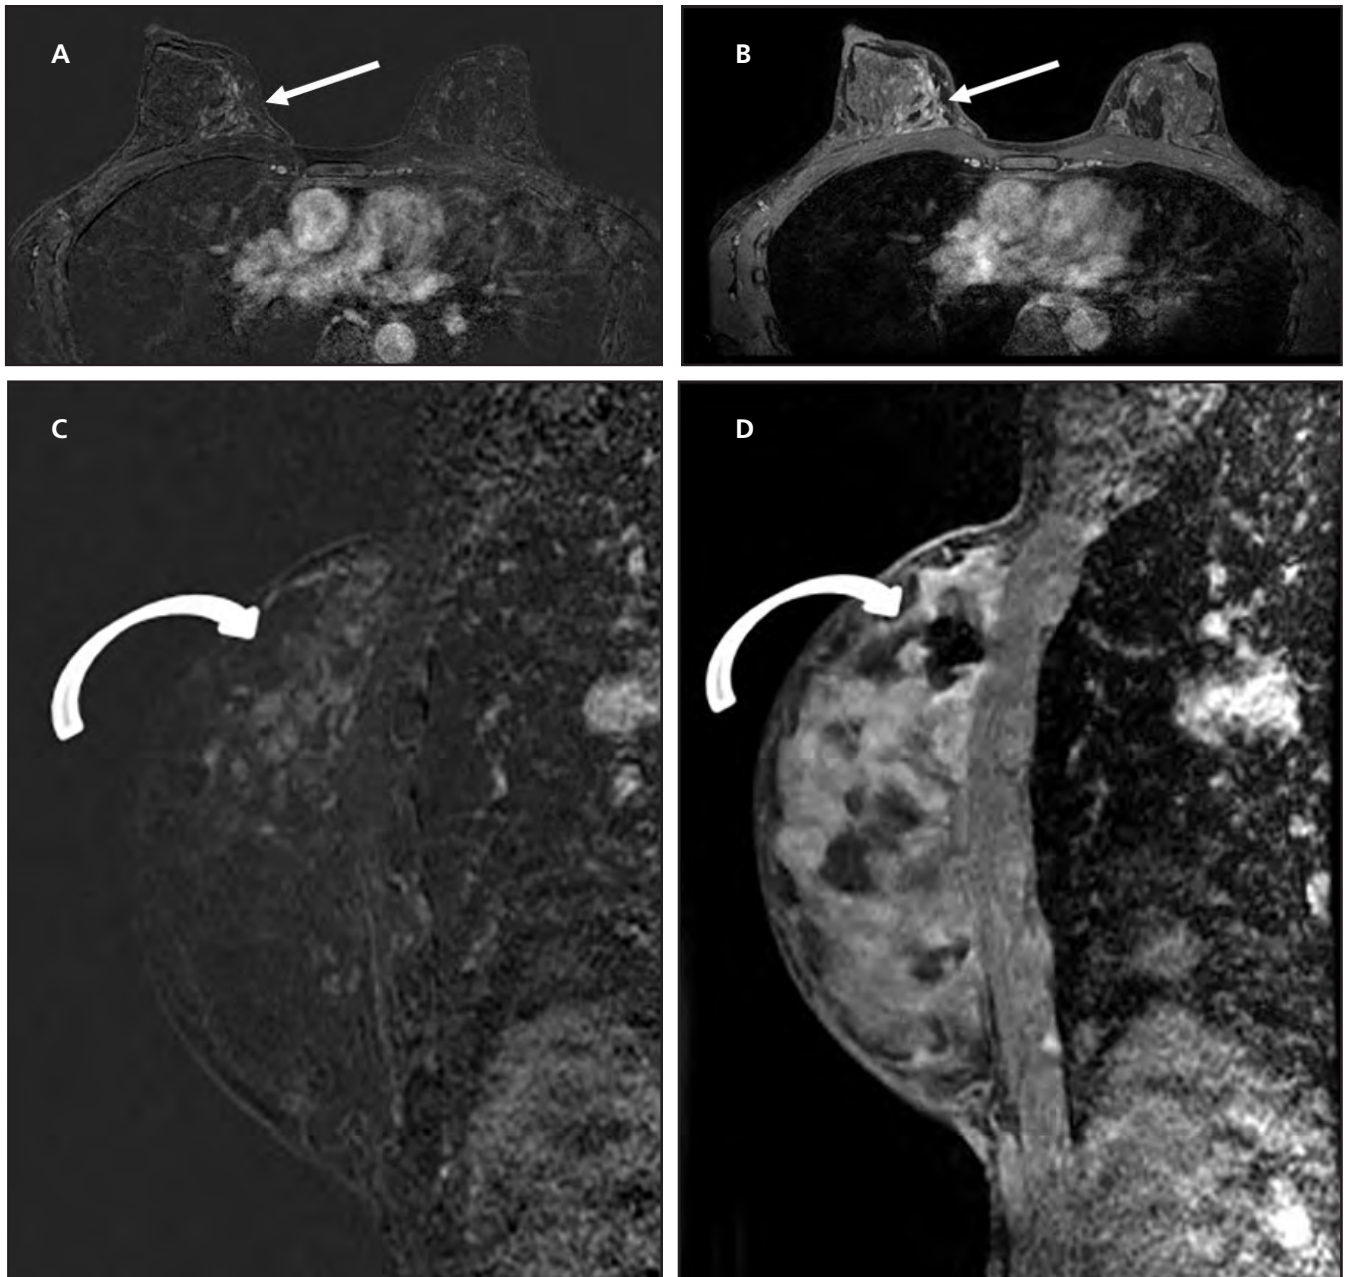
FEA on MRI. A 34-year-old woman demonstrates regional NME in the upper inner quadrant of the right breast on postcontrast axial images marked by the white straight arrows (A, B). Biopsy was recommended and sagittal subtraction prebiopsy and sagittal postcontrast T1FS post-biopsy images demonstrates adequate sampling of the targeted area marked by the curved arrows (C, D). Pathology demonstrated FEA and ALH. No upgrade at surgical excision.
